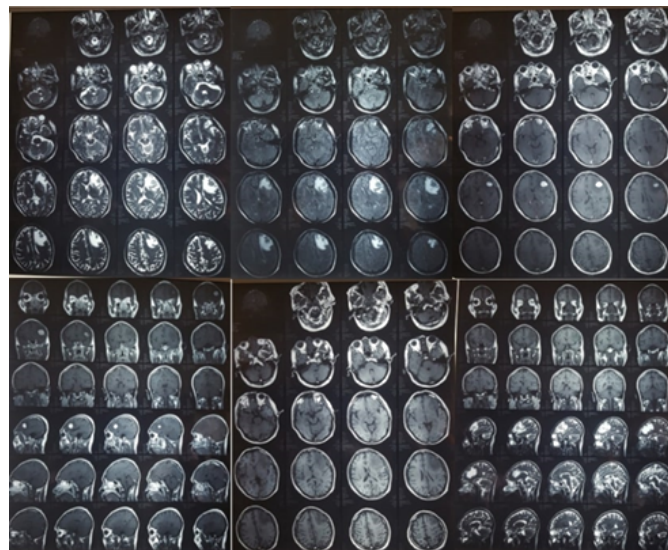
Pre-surgical head MRI with contrast.
